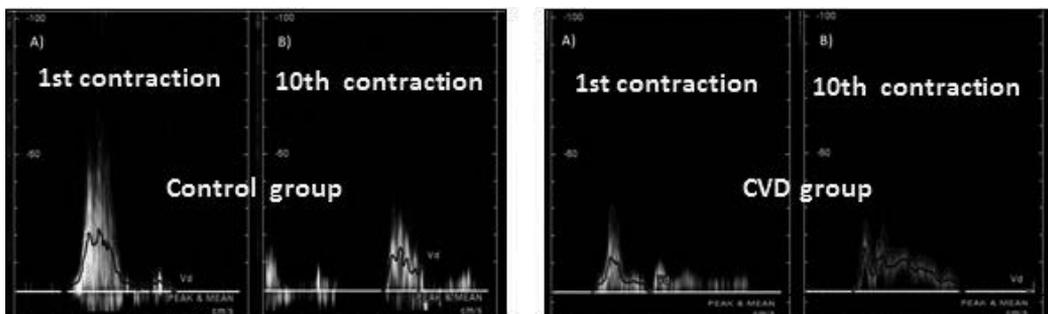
Venous ultrasound assessment at popliteal vein during 1st and 10th calf contraction. Venous ultrasound assessment at popliteal vein during 1st (A) and 10th (B) calf contraction, during tiptoe movement for both control (no CVD) and CVD (C_0 – C_4) groups.
